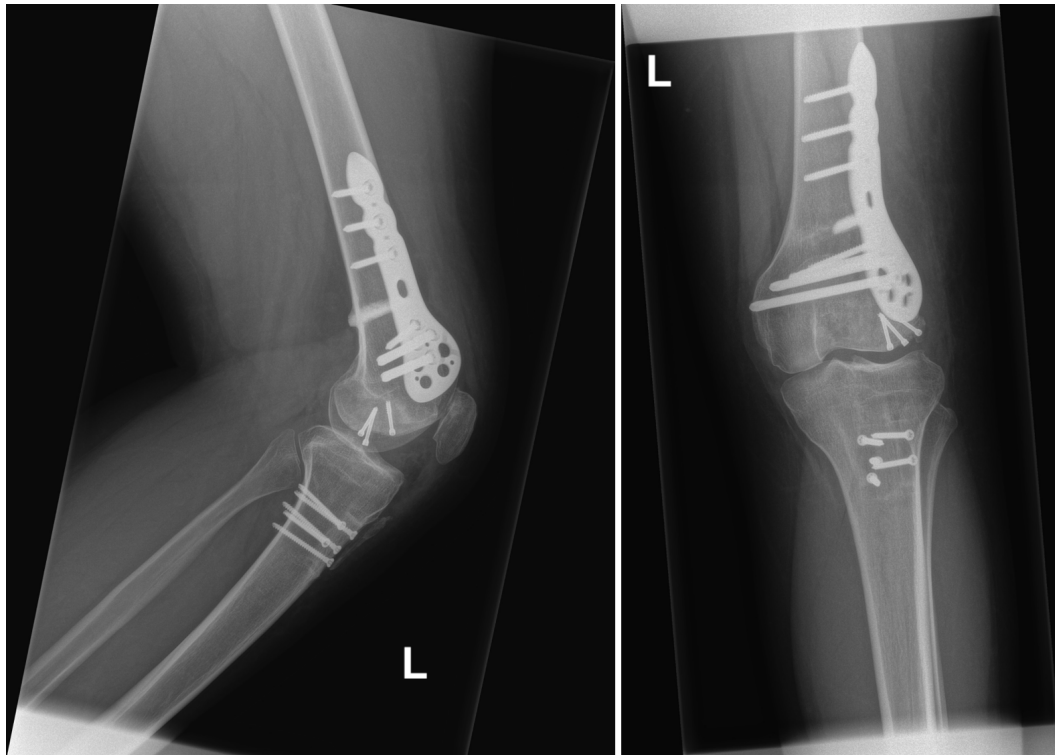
6 months post-OR X-ray images. On the left an AP view of the knee is seen and on the right the lateral view. The patella is situated in front of the trochlear groove.
